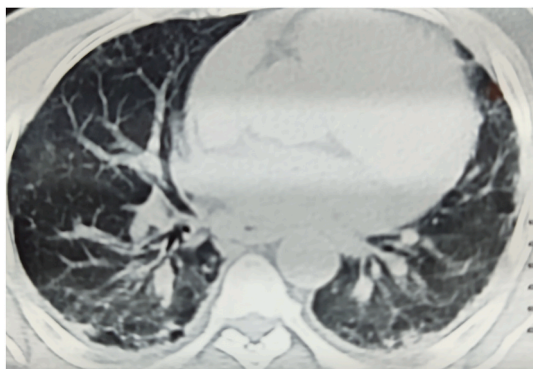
Thoracic CT scanning favor of a pneumopathy with sars cov 2 with lung damage between 10 and 25%.
